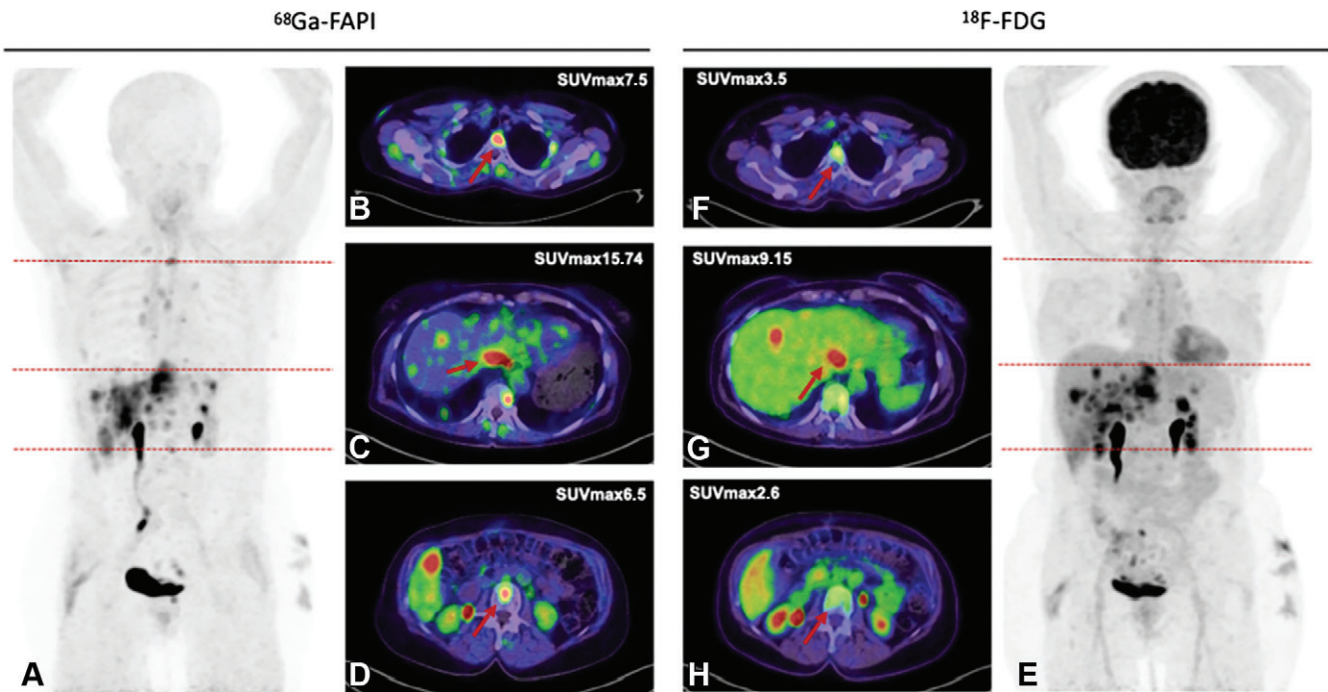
Images in a 63-year-old woman with metastasized ovarian carcinoma who underwent gallium 68 (^{68}Ga)-labeled fibroblast activation protein inhibitor (FAP) PET/CT (left images) followed by fluorine 18 (^{18}F) fluorodeoxyglucose (FDG) PET/CT (right images) 1 month later. (A, E) Anterior maximum intensity projection images from ^{68}Ga -FAP PET (A) and ^{18}F -FDG PET (E). (B–D, F–H) Axial fused PET/CT images depict bone metastases in the upper thoracic spine (B, F; arrow) and the lower thoracic spine (D, H; arrow) and a liver metastasis in segment I (C, G; arrow) with a rather high FAPI uptake (left images) compared with FDG (right images) (maximum standardized uptake value [SUV_{max}] of FAPI vs FDG: 7.5 vs 3.5, respectively, in the bone metastasis in the upper thoracic spine, 6.5 vs 2.6 in the bone metastasis in the lower thoracic spine, and 15.7 vs 9.2 in the liver metastasis). (Adapted, under a CC BY license, from reference 13.)
